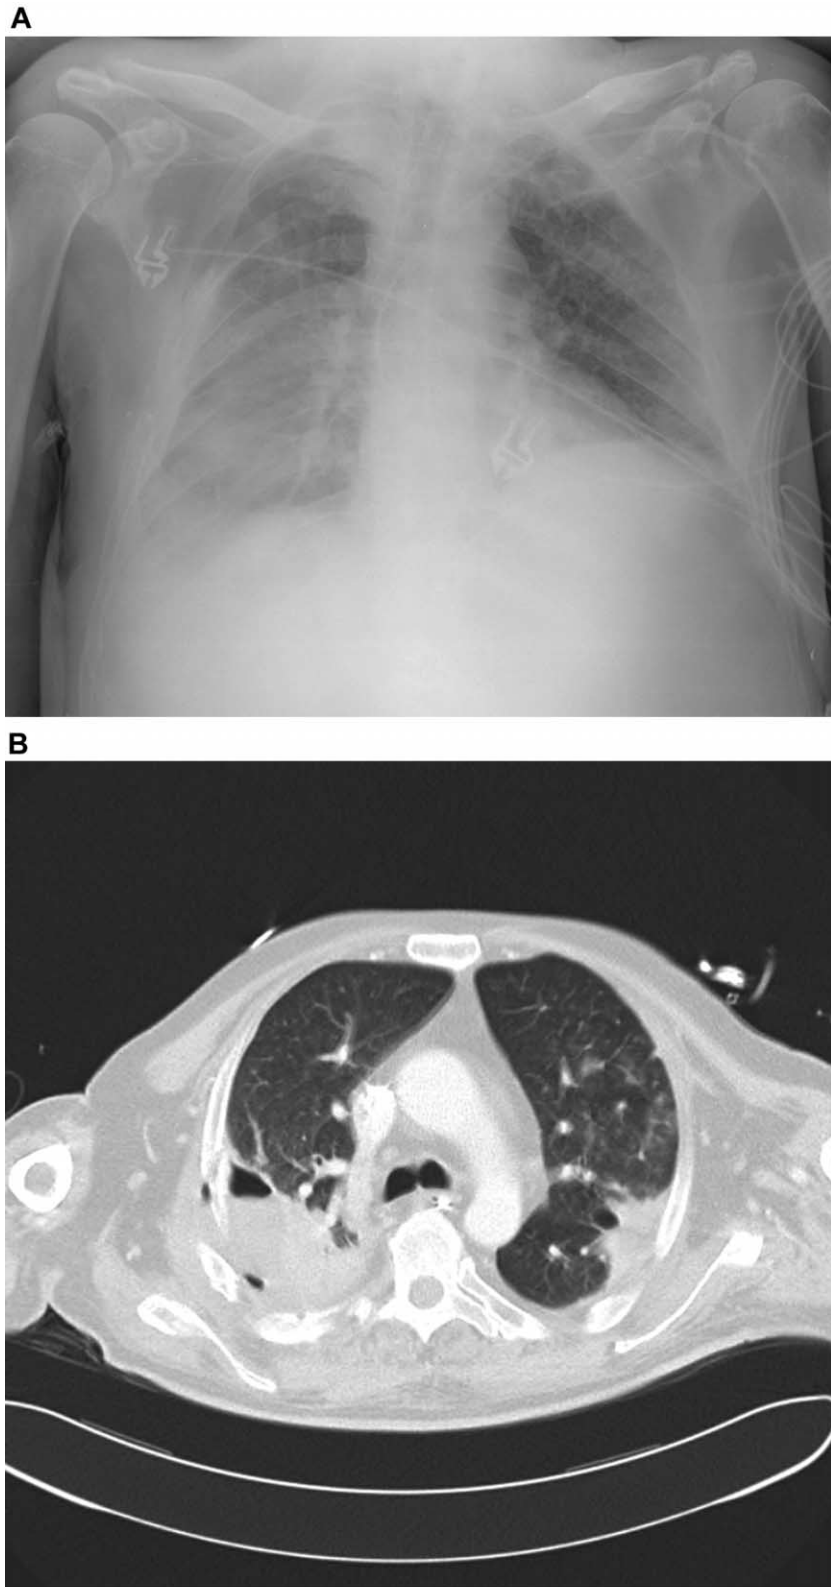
Chest radiograph (A) and CT (B) for a patient who was receiving high-dose steroids because of graft-versus-host disease 4 months after undergoing bone marrow transplantation for acute myeloid leukemia. Chest radiography revealed a right-side pleural effusion and adjacent lung infiltrate. CT confirmed a right-side complicated parapneumonic effusion, a mass filled partially with air between the fourth and fifth rib (with partial destruction of the bone), and a wedge-shaped infiltrate on the left side. The pleural fluid culture grew *Aspergillus fumigatus*. Findings are compatible with a bronchopleural fistula, secondary to rupture of a cavitating infiltrate and adjacent bone destruction.
